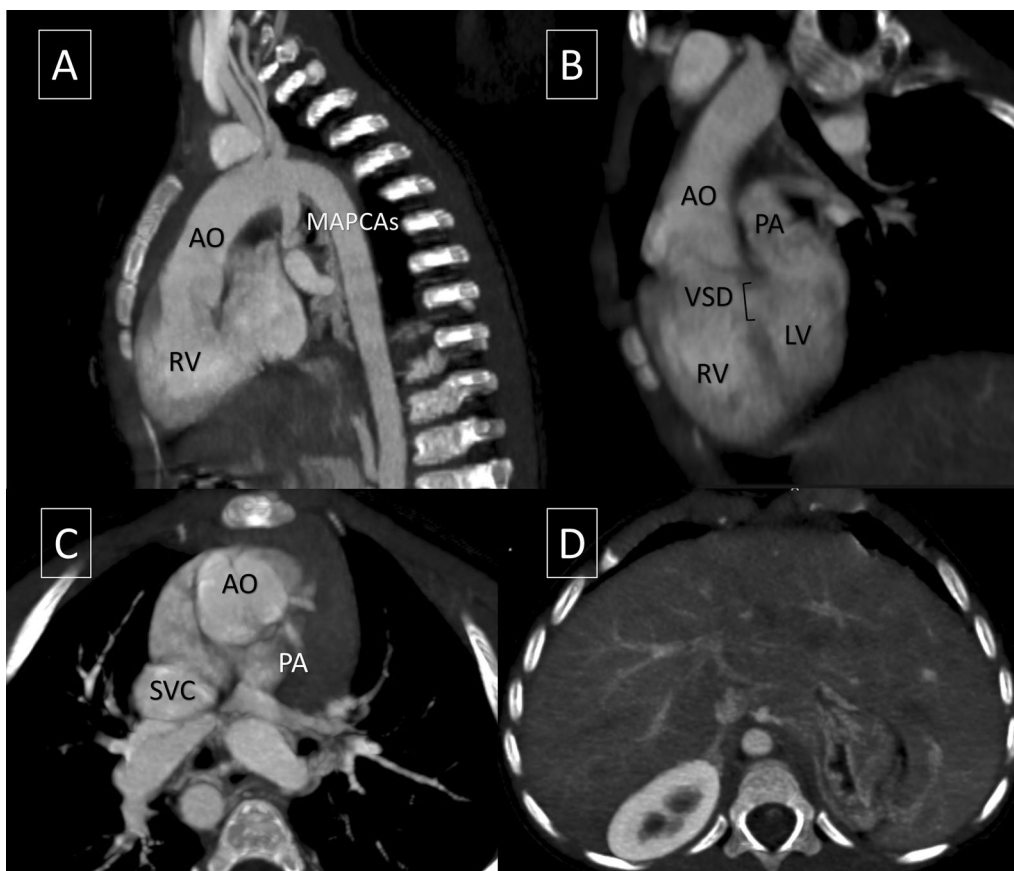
Sagittal, coronal and axial section of cardiac CT angiography of the cardiac vasculature. Aortic root is originated from the right ventricle (RV). The aorta continues on the right side, with an apparent connection to the right pulmonary aberrant artery at the level of the aortic arch via the major aortopulmonary collateral arteries (MAPCAs) (A). Main pulmonary artery originates from left ventricle and appears atretic with only connection to the left pulmonary artery (PA) (B, C). Aortic valve is located on the anterior right to the pulmonary valve confirming the spatial relationship of semilunar cusps in D-TGA (C). The liver is transversal in position and located in the midline, and no spleen was identified, suggesting a possible heterotaxy syndrome, along with the cardiac anomaly (D)
